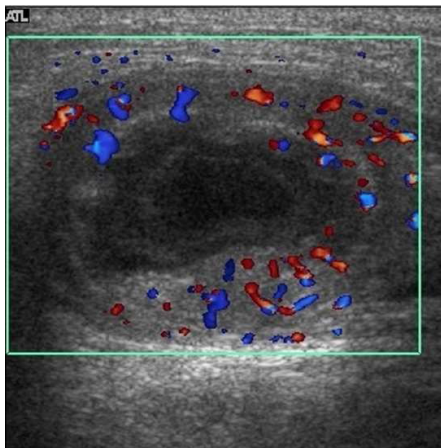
Color doppler image exhibiting central lower echogenicity, wall thickness, and vascularity in the peripheral region.
